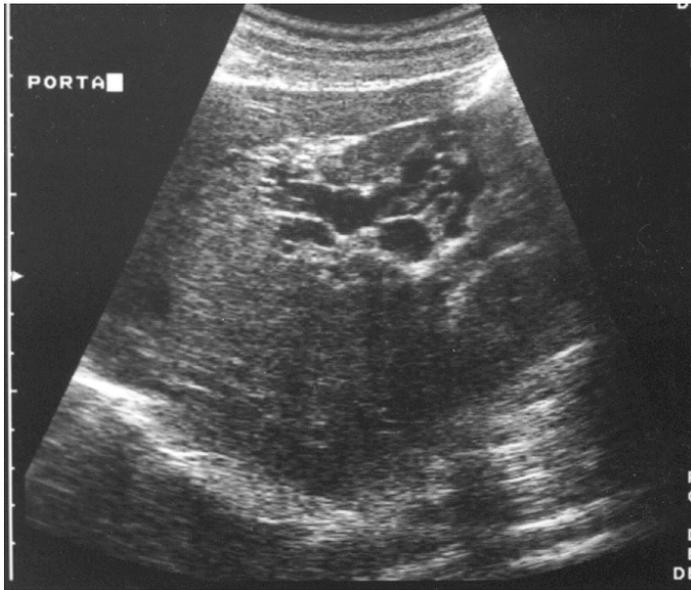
Ultrasonography of a portal cavernoma.
